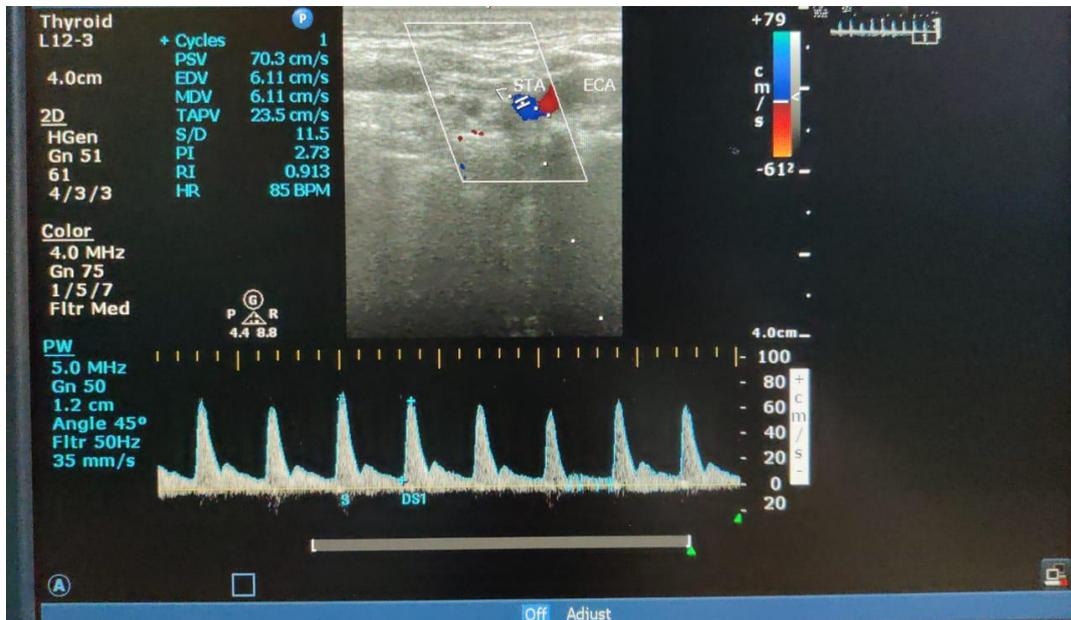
On USG there was a large ill-defined, taller than wider, solid cystic lesion with few areas of calcification within noted in the left lobe of thyroid. On Doppler interrogation there is increased vascularity and raised Doppler indices[PSV-70 cm/sec, PI-2.7, RI-0.9]-TIRADS-5
